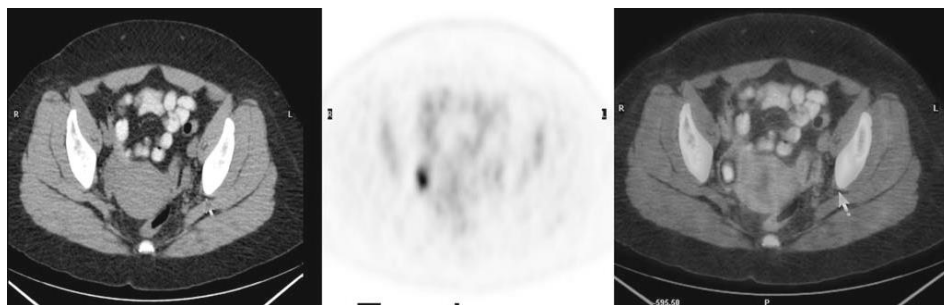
PET/CT images shows ovarian corpus luteum cyst uptake
